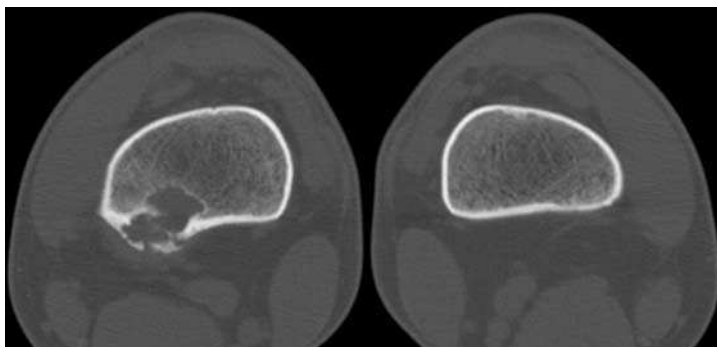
CT image of affected bone and contra-lateral bone.
